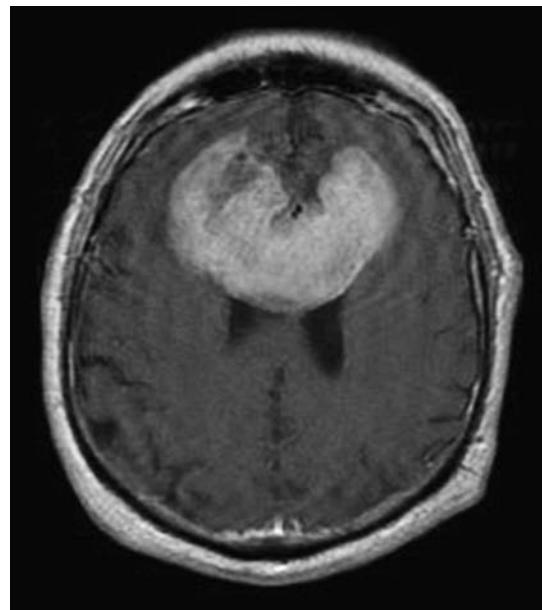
Postgadolinium T1 MRI demonstrating a large bifrontal primary central nervous system lymphoma (PCNSL). The periventricular location and diffuse enhancement pattern are characteristic of lymphoma.
